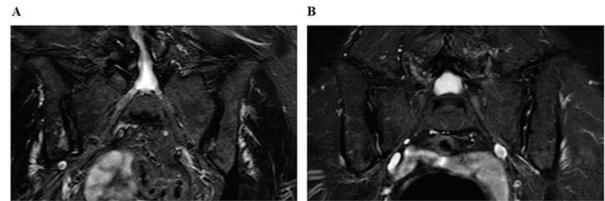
Magnetic resonance imaging of the sacroiliac joints using short tau inversion recovery in a female patient with radiographic axial spondyloarthritis (Case 4) (A) immediately before starting upadacitinib, showing bone marrow oedema and (B) after 1 year of upadacitinib showing resolution of oedema.
